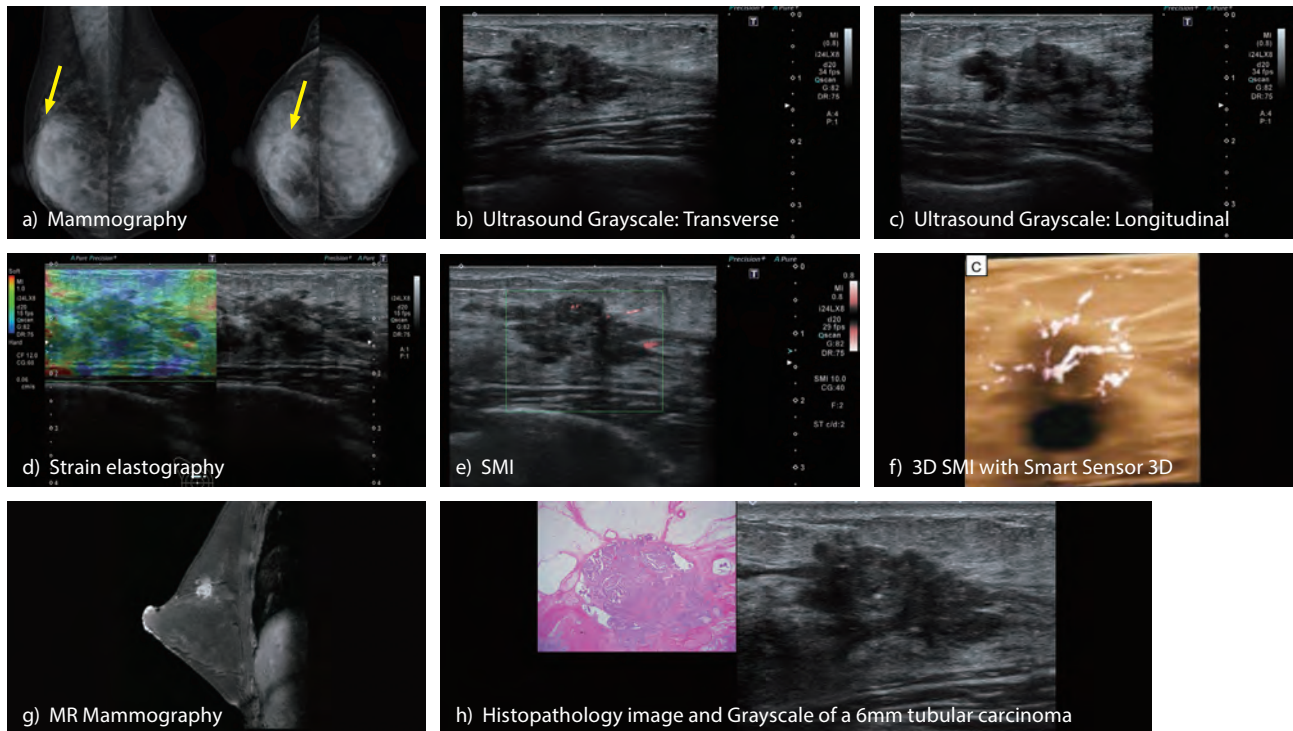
Case 1: A 29-year-old female underwent post mammogram breast ultrasound which detected additional abnormalities
